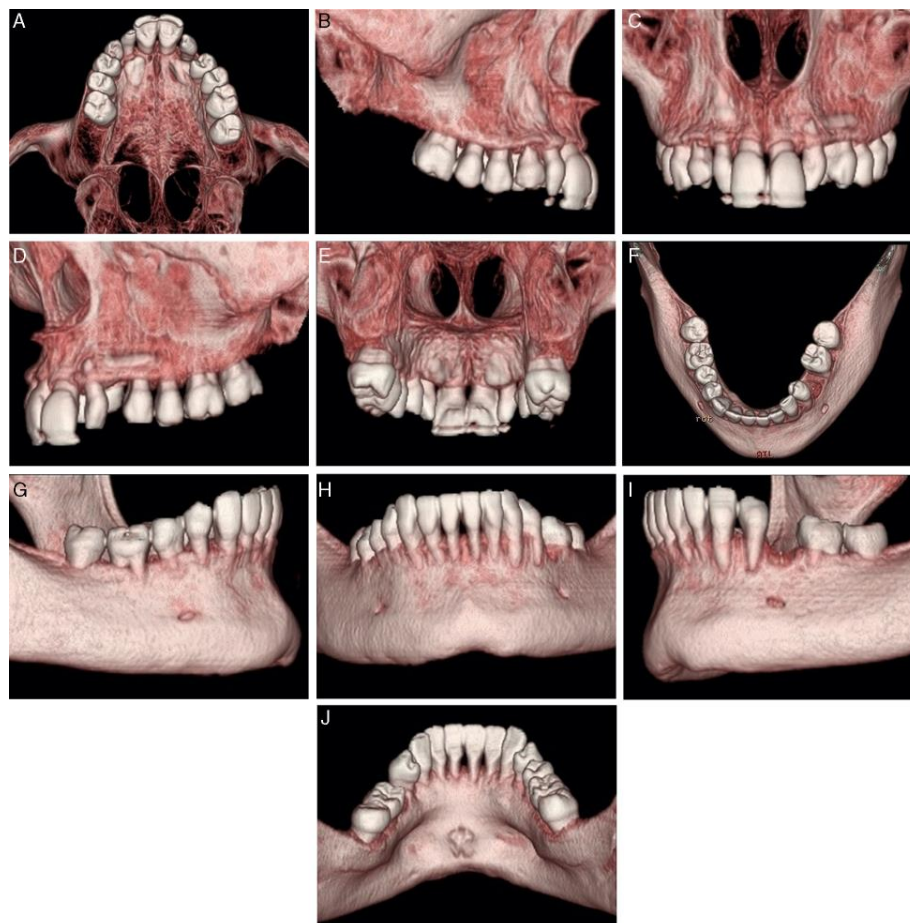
Computed tomography, 3D reconstruction – upper (A) occlusal, (B) right side, (C) front side, (D) left side, (E) posterior side and lower, (F) occlusal, (G) right side, (H) front side, (I) left side, (J) posterior side.
